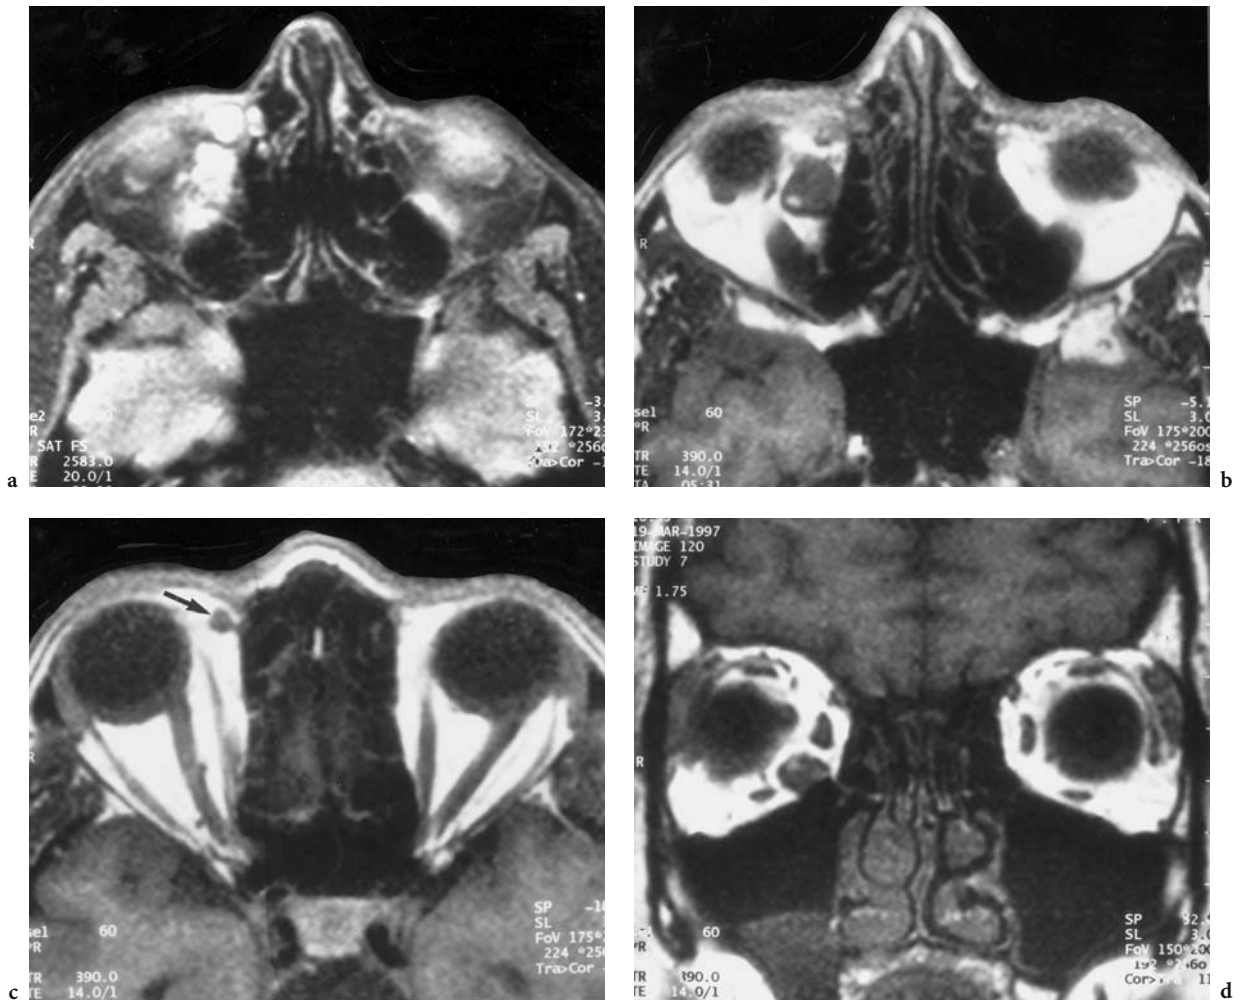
A 41-year-old woman with recurrent lid swelling in the right inferior periorbital to lid region. Diagnosis: pre- and postseptal varicosis. MRI: a Axial proton-weighted view of the inferior orbit with multilobulated, cystic formation in the right medial inferior orbit. b Axial T1-weighted view acquired a few millimeters above a. c Axial T1-weighted view at the level of the optic nerve identifying another small extraconal formation (*small arrow*). d Coronal view (pressure exerted) showing the most prominent of the venous enlargements on the tendinous parts of the muscle cone from inferomedial
